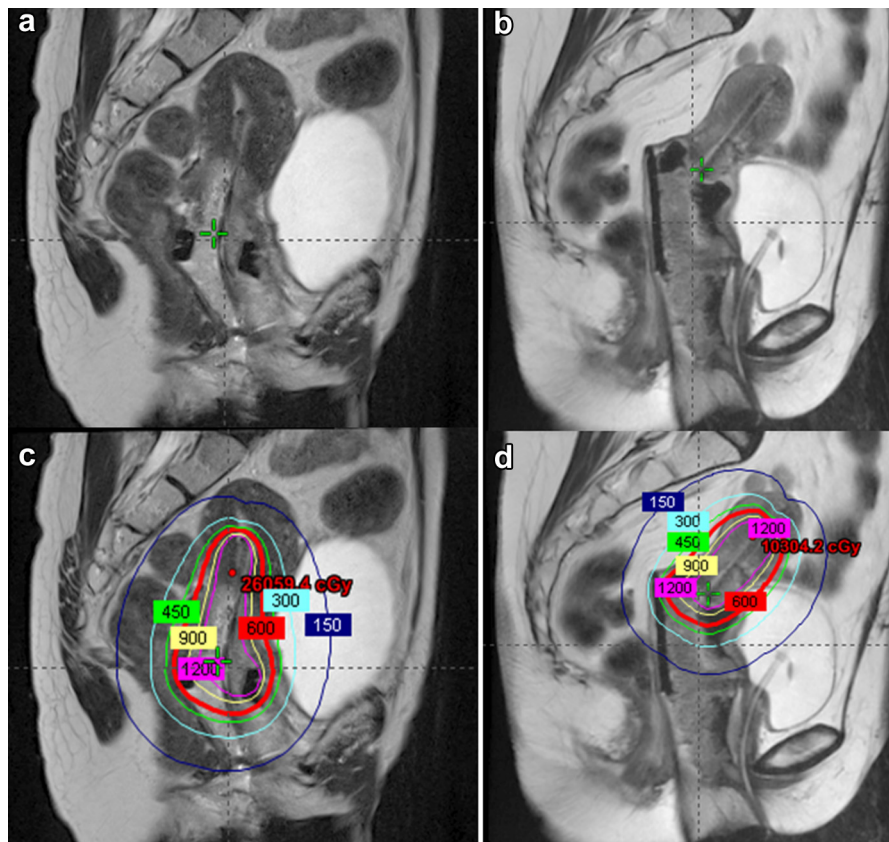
Images taken from two different brachytherapy treatments with and without rectal retractor showing rectal displacement effects for each technique. Image (a) shows applicator placement without a rectal retractor. Image (c) shows this same application with dosimetry overlaid on MRI image. Image (b) shows applicator placement with a rectal retractor. Image (d) shows this same application with dosimetry overlaid on MRI image.
